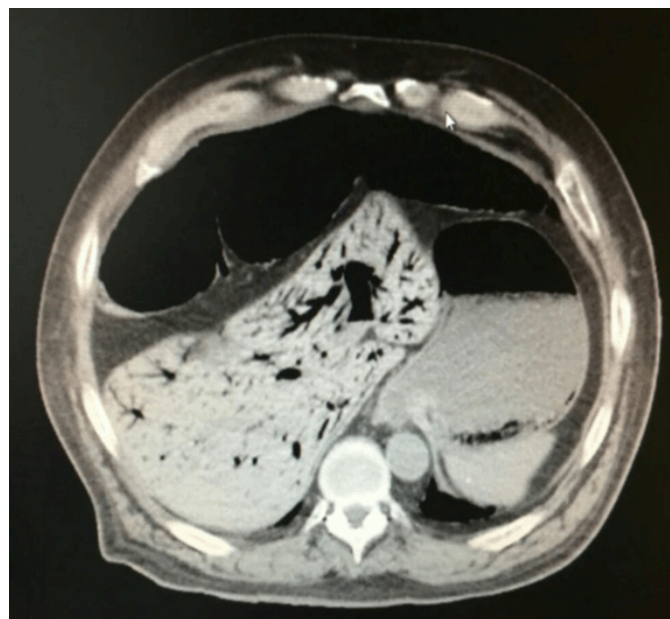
Computed tomography scan of the abdomen showing hepatic portal venous gas with branching pattern and a peripheral distribution.
